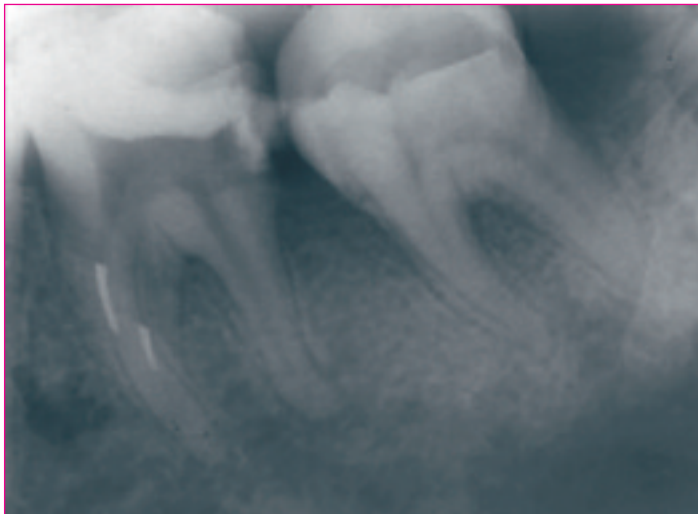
The diagnostic radiograph shows a first lower molar with two separated Rotary Ni-Ti files inside the mesial root.
